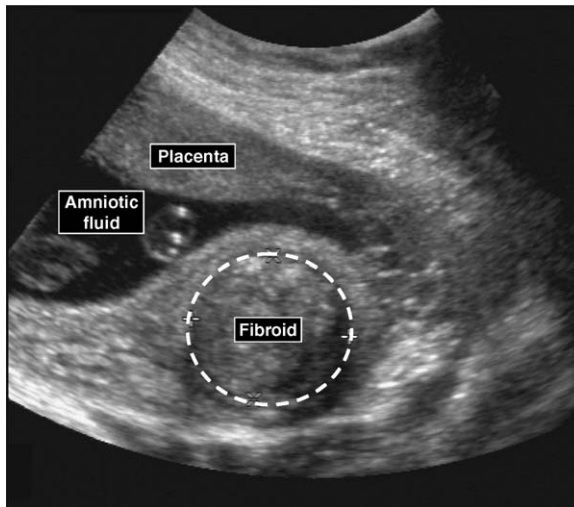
Fibroid distorting the uterine cavity. A transabdominal ultrasound image of a 16-week pregnancy is shown. The placenta is located anteriorly. A large (4.8×4.3 cm) submucosal fibroid can be seen in the posterior uterine wall and is distorting the uterine cavity.
